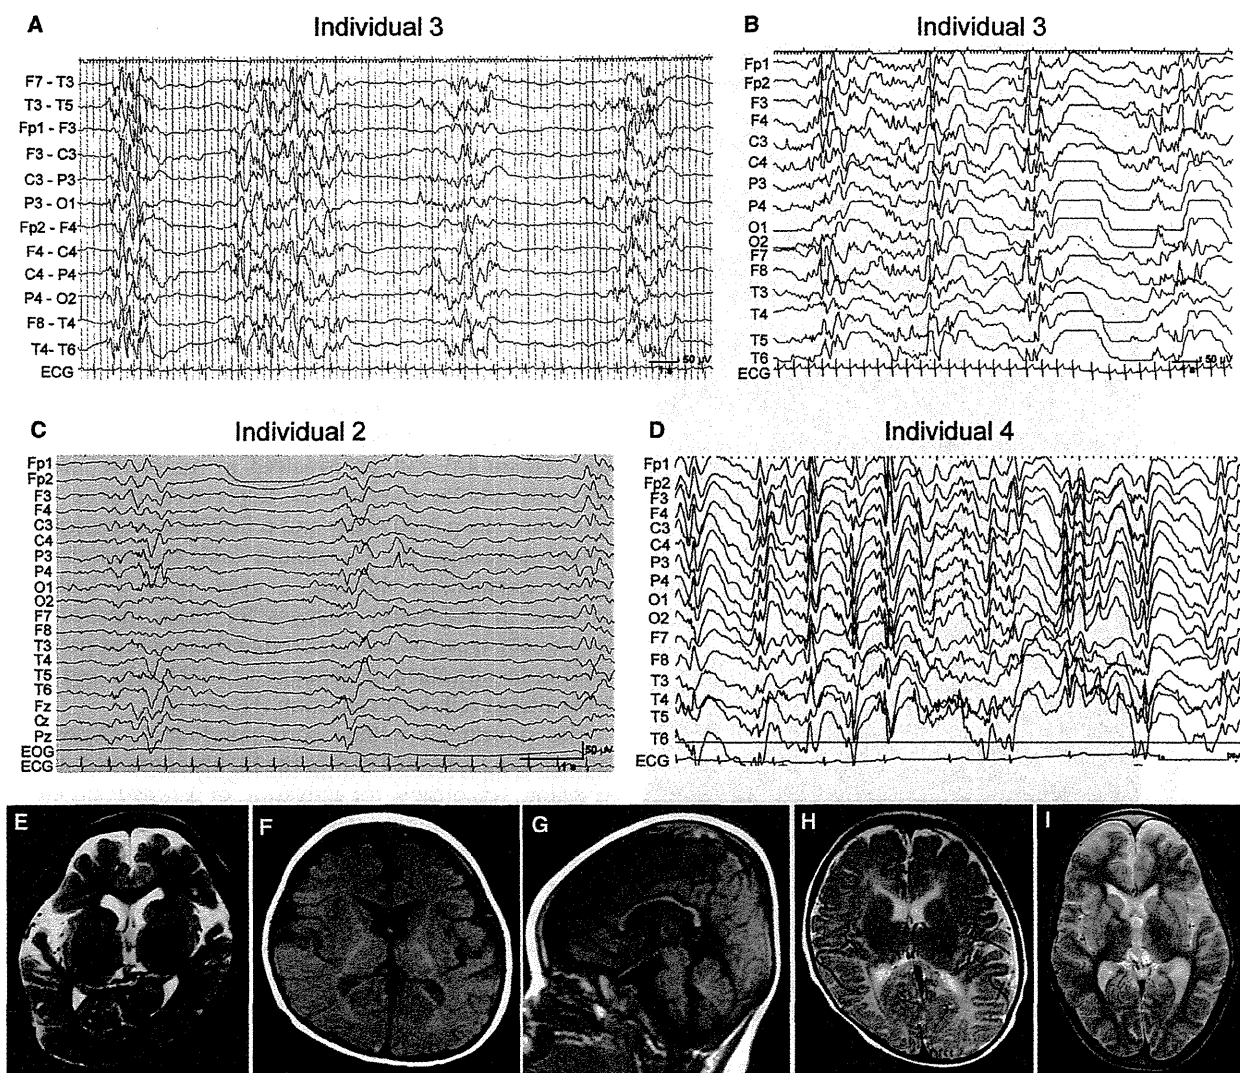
EEG and Brain MRI Features of Individuals with *GNAO1* Mutations
